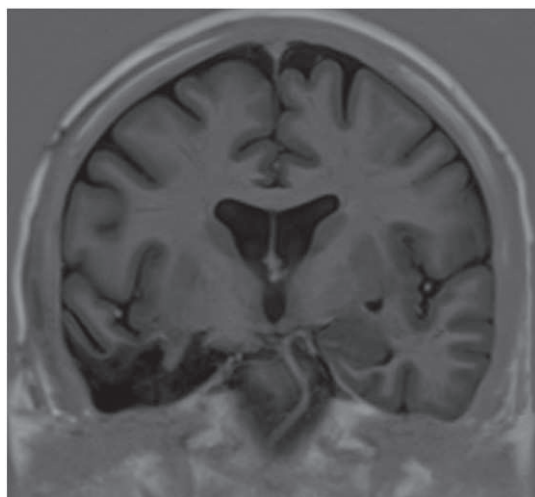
C.B.'s 1-year postoperative MRI inversion–recovery coronal slice.
